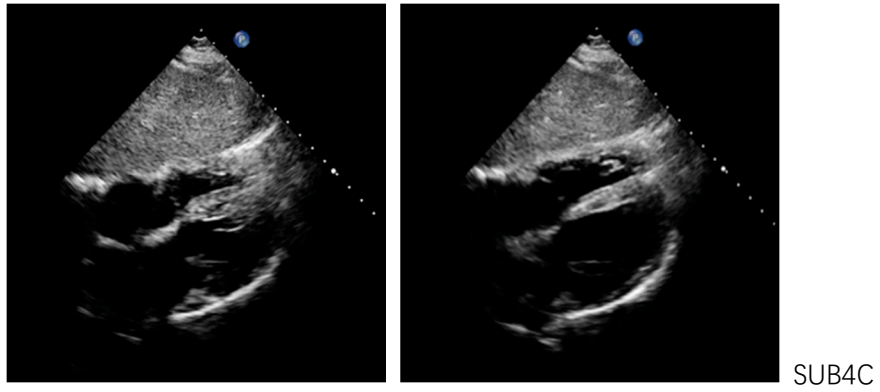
Ultrasound images of nine standard cardiac views during cardiac cycles. There are 2 images in each row, the left is the image in systole and the right is in diastole.
